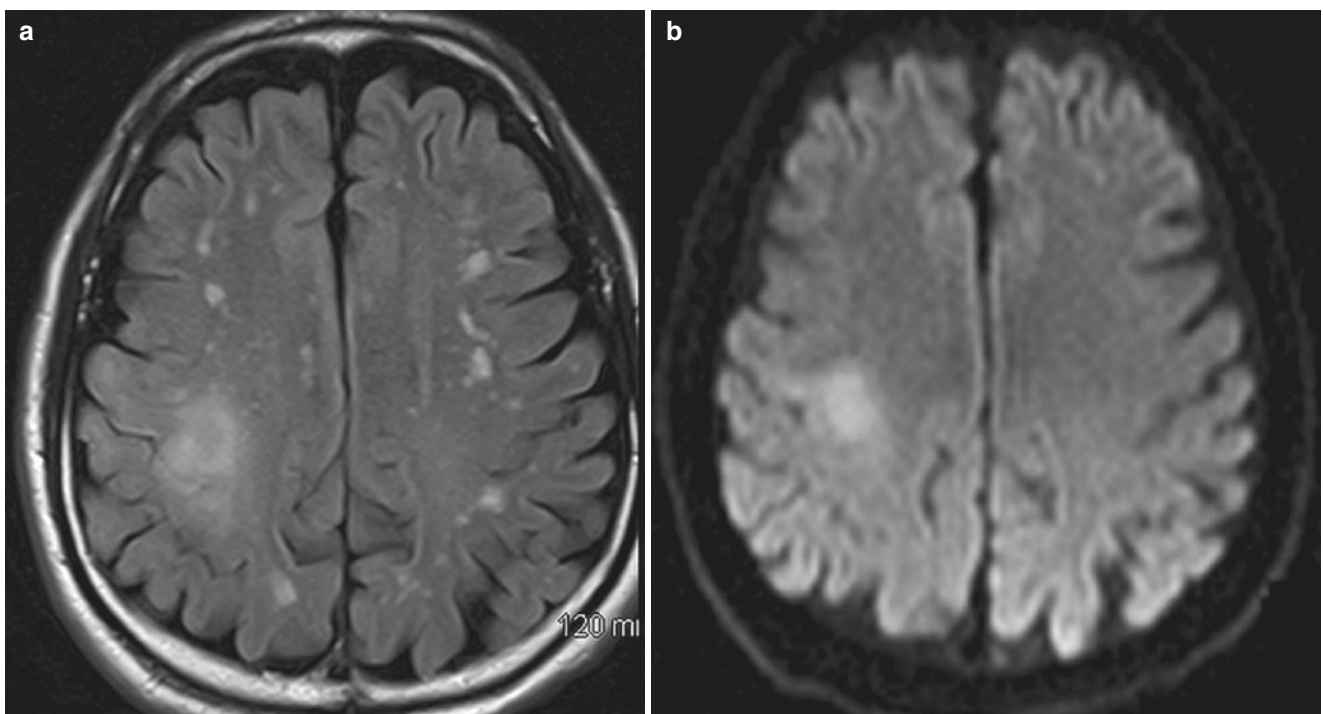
Tumor mimicking infarction. 55-year-old with left-sided weakness. NCCT is normal (not shown). MRI brain shows FLAIR hyperintensity (a) and diffusion restriction (b) in the right peri-rolandic region, initially suspicious for acute or subacute stroke. No enhancement is seen. CTA demonstrates no large vessel occlusion or stenosis.
